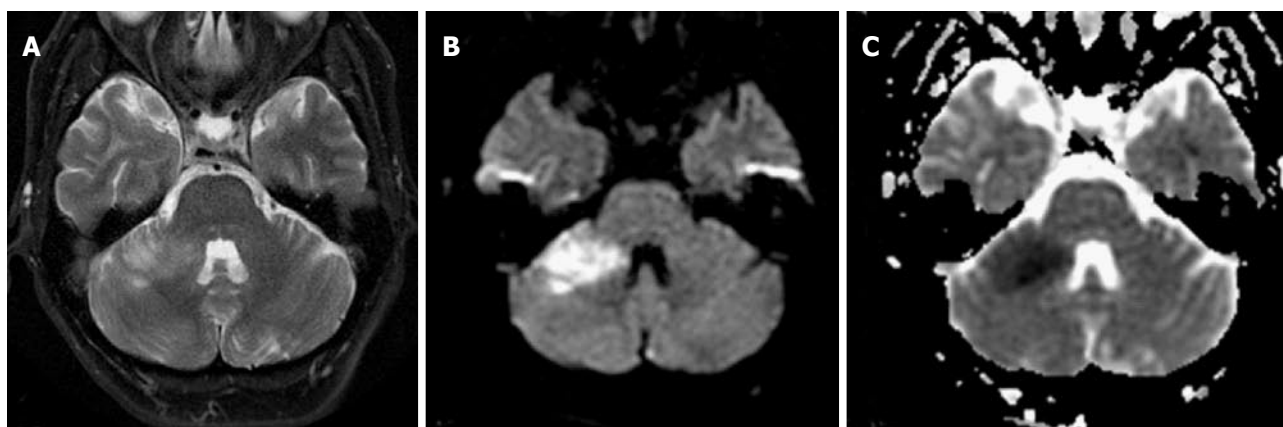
Anterior inferior cerebellar artery infarct. Patient with acute cerebellar ataxia and right-sided weakness. Axial T2 (A), DWI (B) and ADC maps (C) show well-defined area of high T2 signal and restricted diffusion consistent with ischemia. DWI: Diffusion weighted-imaging.
